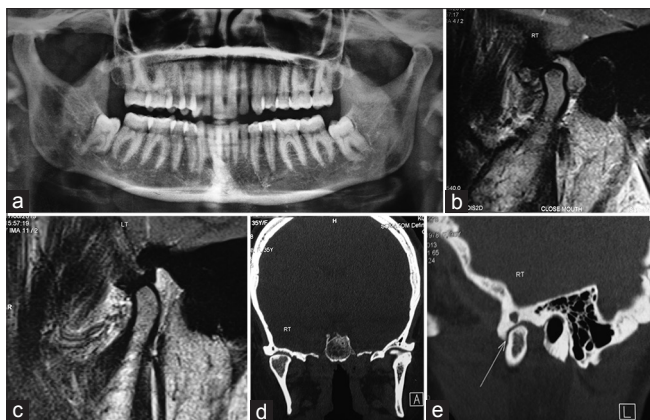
(a) Preoperative orthopantomography of the patient with decreased joint space in the right temporomandibular joint. (b) Magnetic resonance imaging image with posteriorly displaced articular disc in relation to right condyle in closed mouth. (c) Magnetic resonance imaging image of the left condyle with normal disc position in closed mouth. (d) Coronal section of computed tomography with osteophytes in the right condyle. (e) Sagittal section image of the right temporomandibular joint with decreased disc space
